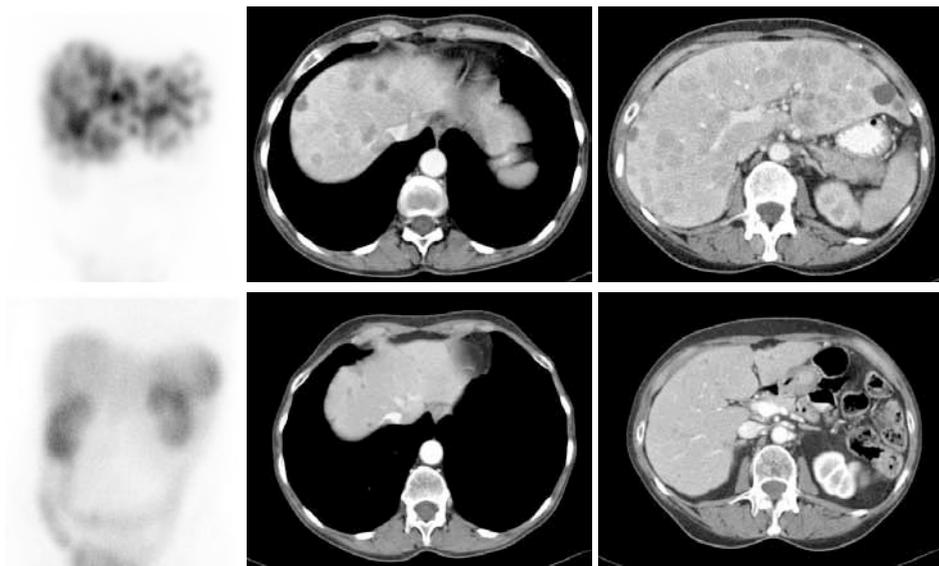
Example of partial remission in a patient with a metastasised carcinoid treated with 29.8 GBq [$^{177}\text{Lu-DOTA}^0, \text{Tyr}^3$]octreotate. Upper row: left panel: scintigraphy (anterior abdomen) after first cycle with [$^{177}\text{Lu-DOTA}^0, \text{Tyr}^3$]octreotate demonstrated extensive somatostatin receptor positive liver metastases. Middle and right panel: CT scan before starting treatment demonstrated these liver metastases. Lower row: left panel: scintigraphy (anterior abdomen) after fourth cycle with [$^{177}\text{Lu-DOTA}^0, \text{Tyr}^3$]octreotate could not visualise liver metastases anymore. Middle and right panel: CT scan after treatment still demonstrated multiple small liver metastases, but metastases clearly regressed in size.
